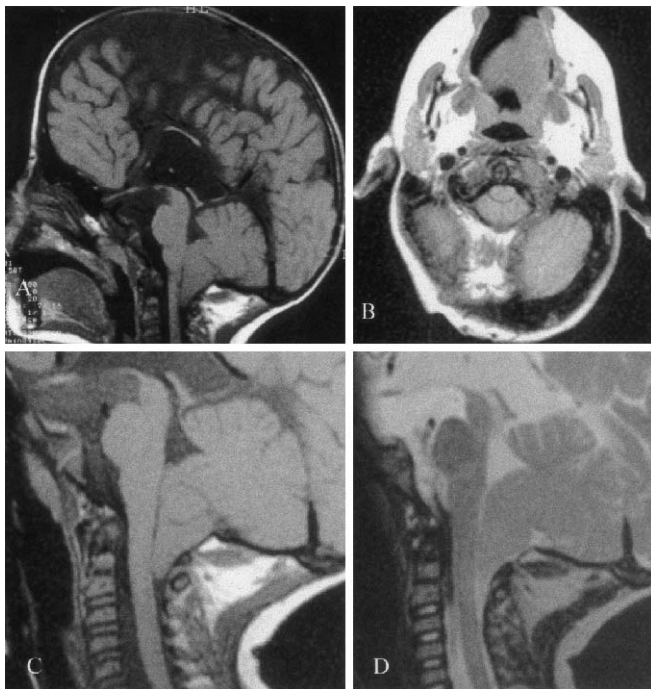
MRI of an 18-month-old boy with syndromic craniosynostosis involving the lambdoid suture. A Midsagittal and B axial T1-weighted images, integrated by posterior fossa and cervical spine, C T1-weighted and D T2-weighted magnifications. The cerebellar tonsils are well displaced into the cervical canal and their tips present an elongated configuration; the subarachnoid spaces at the level of the foramen magnum are obliterated
